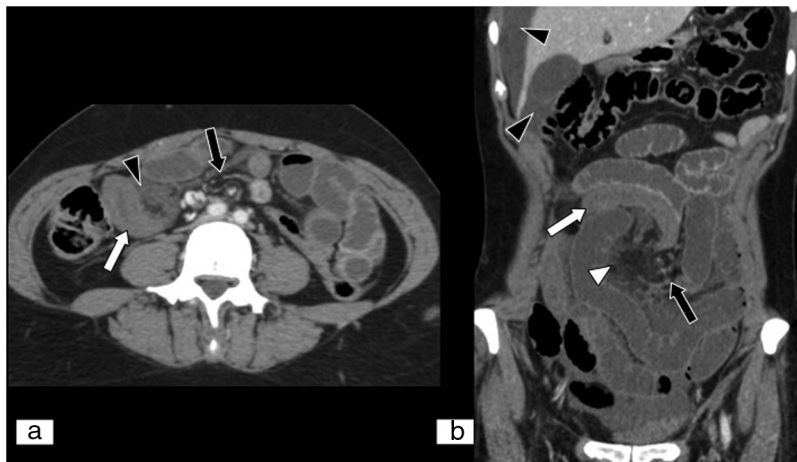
Acute mesenteric ischaemia secondary to internal hernia. Abdominal and pelvic CT scan on an axial plane (A) and MPR reconstruction on a coronal plane of an abdominal and pelvic CT scan (B), both with iodinated intravenous contrast in a portal phase. Loops of small intestine showing parietal thickening and lesser contrast uptake (white arrows), as well as free fluid (black arrow tips) and engorgement of mesenteric vessels, and increased density or striation of fat due to oedema (white arrow tip). Mesenteric vessels with disturbance (black arrows) are seen, due to the presence of an internal hernia.
